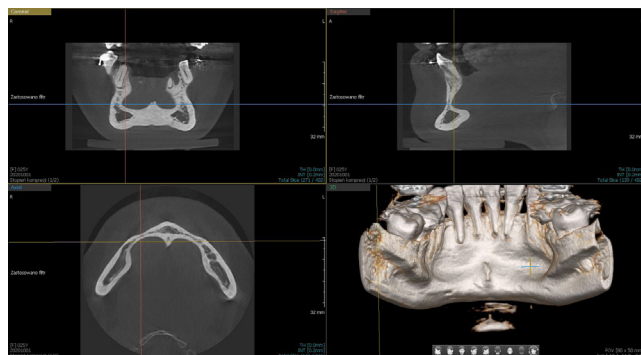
Case 3: Images of the cross-sections of the anterior Stafne bone defect (SBD) in the frontal, sagittal and axial planes in the CBCT examination, and the three-dimensional (3D) mandible model
